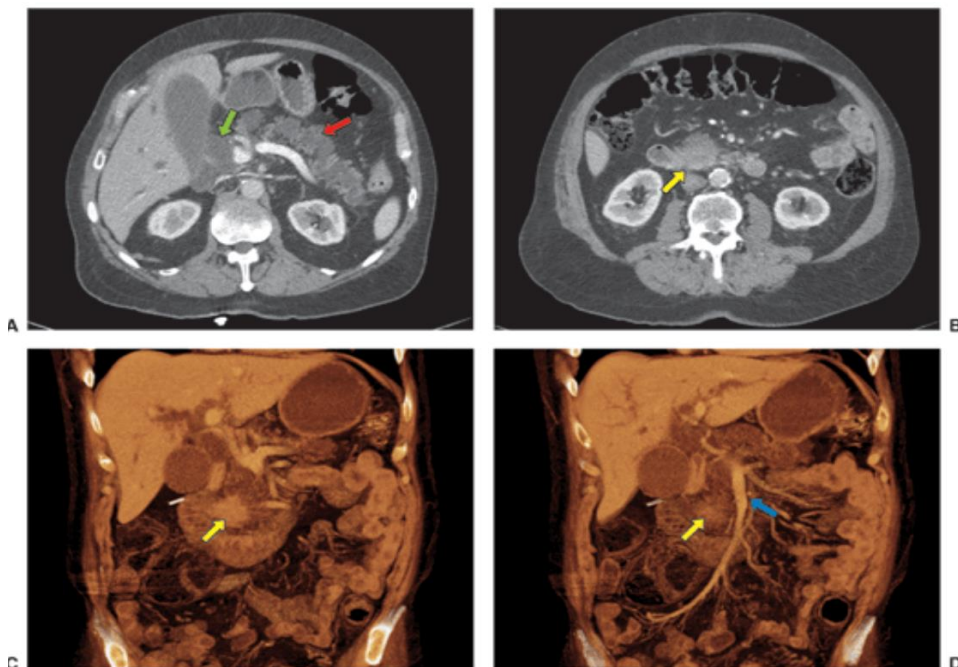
Slices from a triphasic CT scan in a patient with resectable pancreatic cancer. (A) late arterial phase. Double duct sign with dilated common bile and pancreatic ducts, and an atrophic pancreatic body. (B) Mass (C) Coronal reconstruction, venous phase, with the mass apparent, and (D) clearly away from the superior mesenteric-portal vein axis
